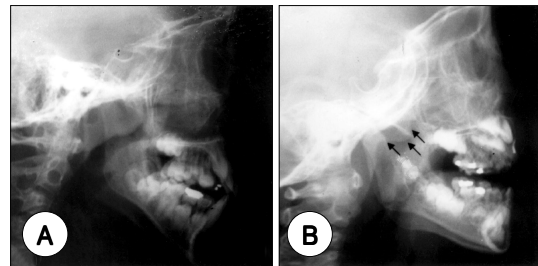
Comparison of preoperative (A) and postoperative (B) radiographic result of conventional adenoidectomy. Arrows indicate the adenoid remnants after conventional adenoidectomy.
